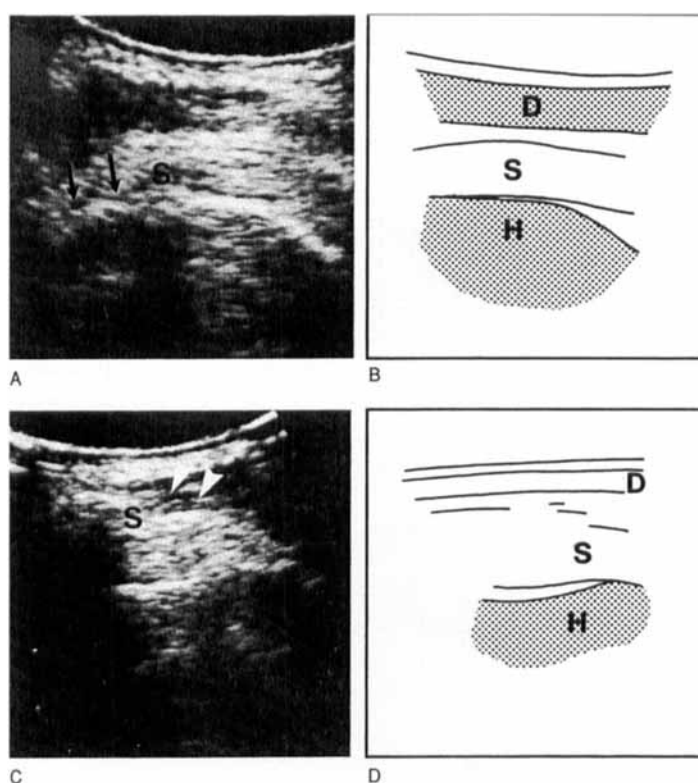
A. and B. Normal sonogram of a right shoulder. Longitudinal section of the supraspinatus tendon (S) and its attachment to the greater tuberosity (arrow). C and D. Left shoulder. Longitudinal section of an enlarged supraspinatus tendon (S). Near the insertion a defect in the structure (arrow) representing a superficial tear. H = humerus, D = deltoid muscle.
